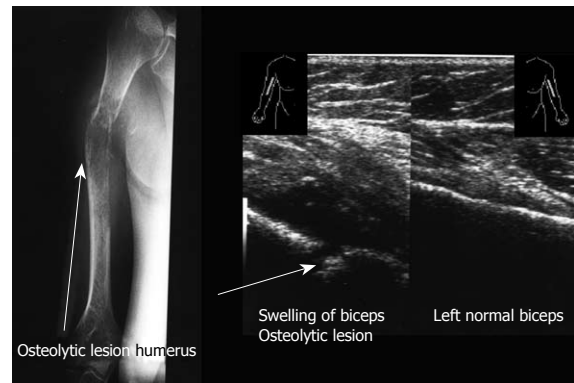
Longitudinal sonogram. Swelling of soft tissue with severe irregularity of the cortex right humerus. Left biceps normal. X-ray of the right arm demonstrates the osteolytic lesion of the right humerus. A 75-year old man presents with swelling of the right humerus, limitation of movement, night pain and weight loss.
